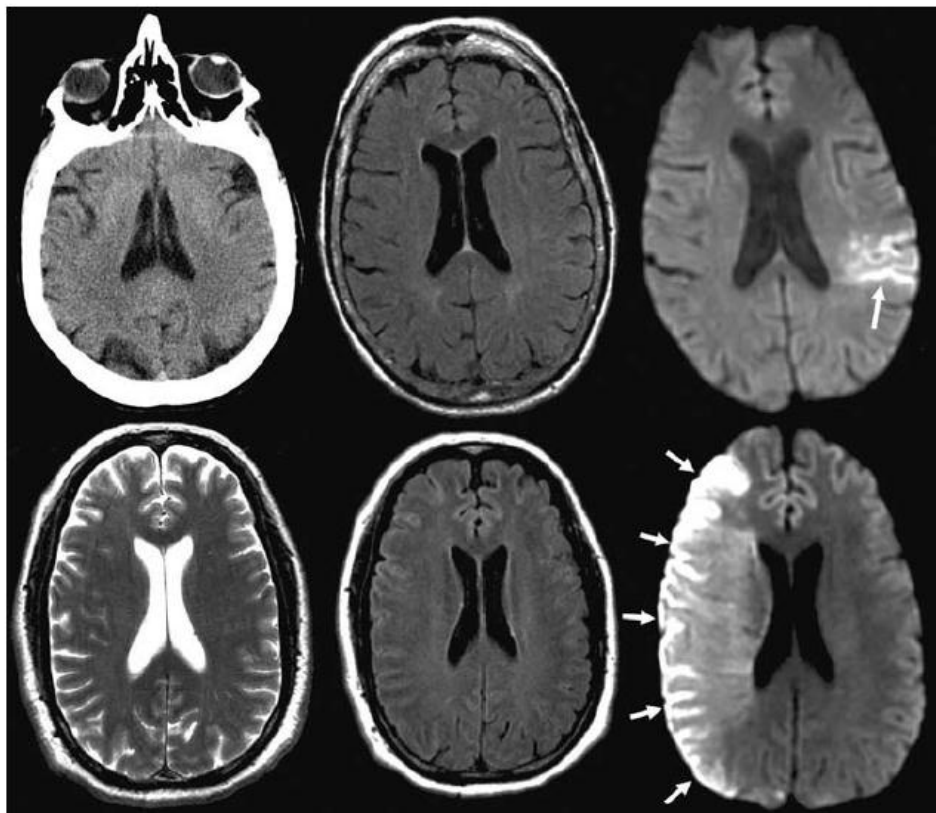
comparison of CT, MRI and diffusion weighted image
